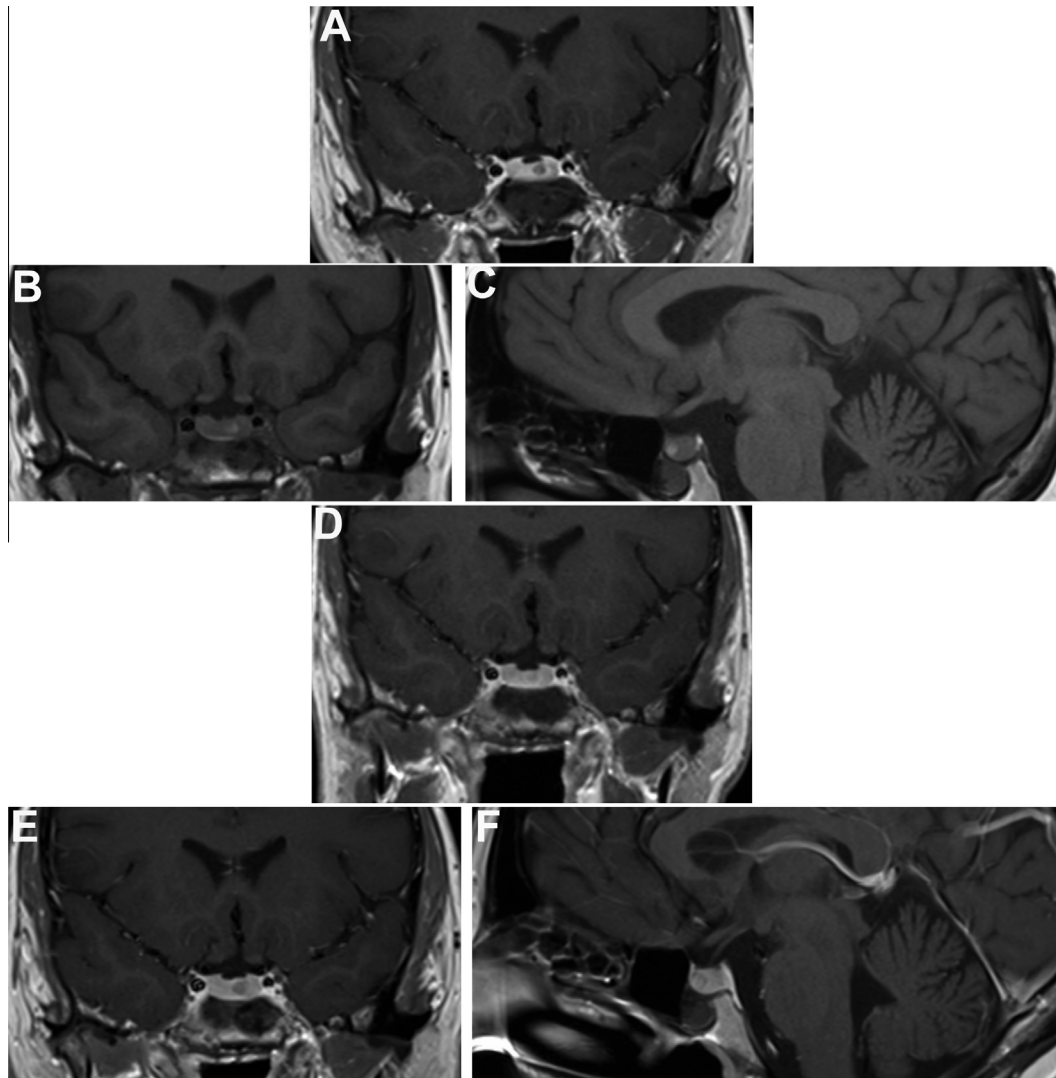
Patient 1. (A) Coronal, T1-weighted, contrast-enhanced MRI at presentation showing the pituitary adenoma. (B) Coronal and (C) sagittal T1-weighted, non-enhanced MRI during the relapse of symptoms, roughly 1 year after the first scan, showing hyperintensity within the previous adenoma, consistent with hemorrhage. (D) Coronal, T1-weighted, contrast-enhanced MRI about 1 year after (B) and (C), after the delivery of her child, while the patient had a normal urinary-free cortisol (29.4 $\mu\text{g}/\text{days}$), showing a less-dense and smaller microadenoma. (E) Coronal and (F) sagittal T1-weighted, contrast-enhanced MRI immediately before surgery showing tumor growth.
